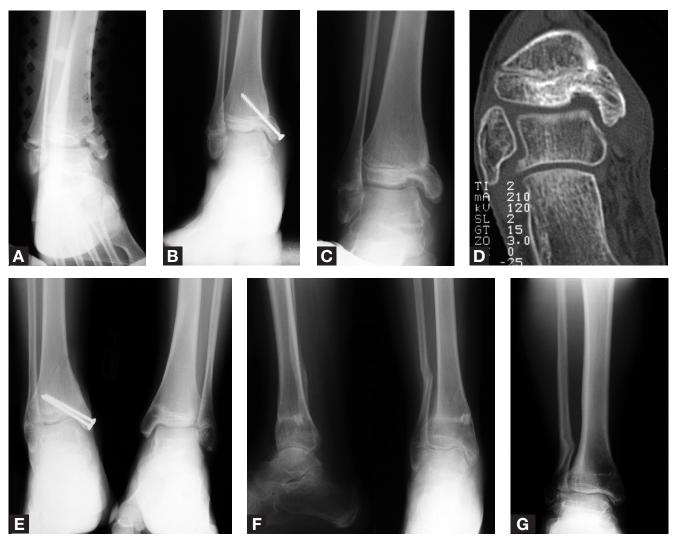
(A) Mortise view of right ankle shows displaced medial malleolus fracture. (B) Mortise view of right ankle 4 months after open reduction and internal fixation (ORIF). (C) Mortise view of right ankle 16 months after ORIF and 1 week after hardware removal. (D) Coronal image of right ankle after hardware removal shows fracture malunion secondary to medial physeal arrest. (E) Anteroposterior (AP) radiograph of bilateral ankles obtained with patient standing 6 months after medial malleolar osteotomy performed to correct malunion. Note varus alignment of ankle mortise. (F) AP and lateral radiographs of right ankle after distal tibial osteotomy to correct varus deformity of right ankle. (G) AP radiograph of right tibia shows anatomical alignment of ankle joint 1 year after distal tibial osteotomy.
